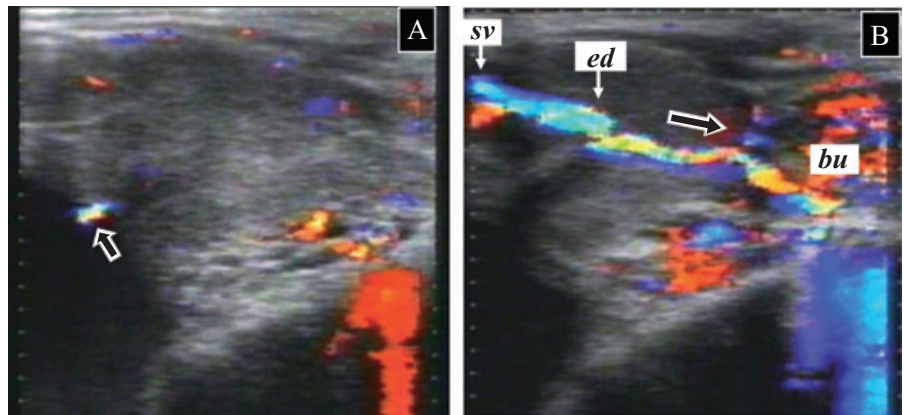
Color Doppler ultrasonographic images of ejaculation in case 3. (A) With oral silodosin. A small amount of semen flows into the bladder (black arrow). (B) Without oral silodosin. Normal ejaculatory stream from seminal vesicles (sv) towards the bulbous urethra (bu) through the ejaculatory duct (ed).
